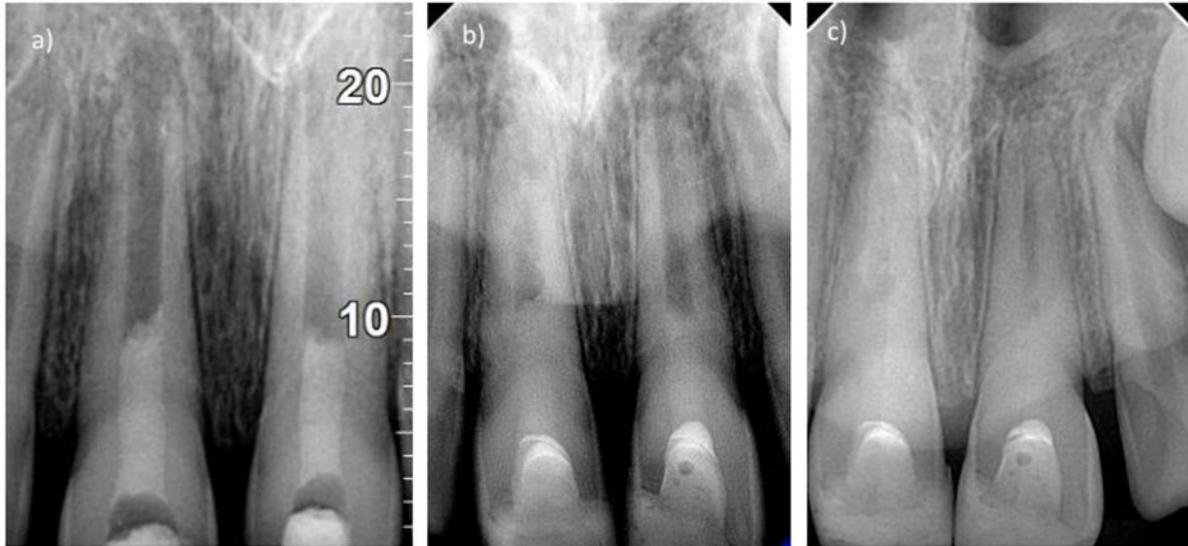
Control X-ray immediately after REP (a) and follow-up X-rays after 6 (b) and 24 (c) months.
